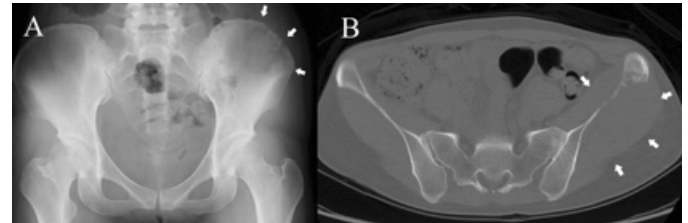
Plain X-ray image showing a predominantly osteolytic lesion in the left iliac crest (A). Axial CT image showing a destructive and moth-eaten appearance involving the left ilium, with the presence of a soft tissue mass on both the medial and lateral sides of the bone (arrows) (B).
